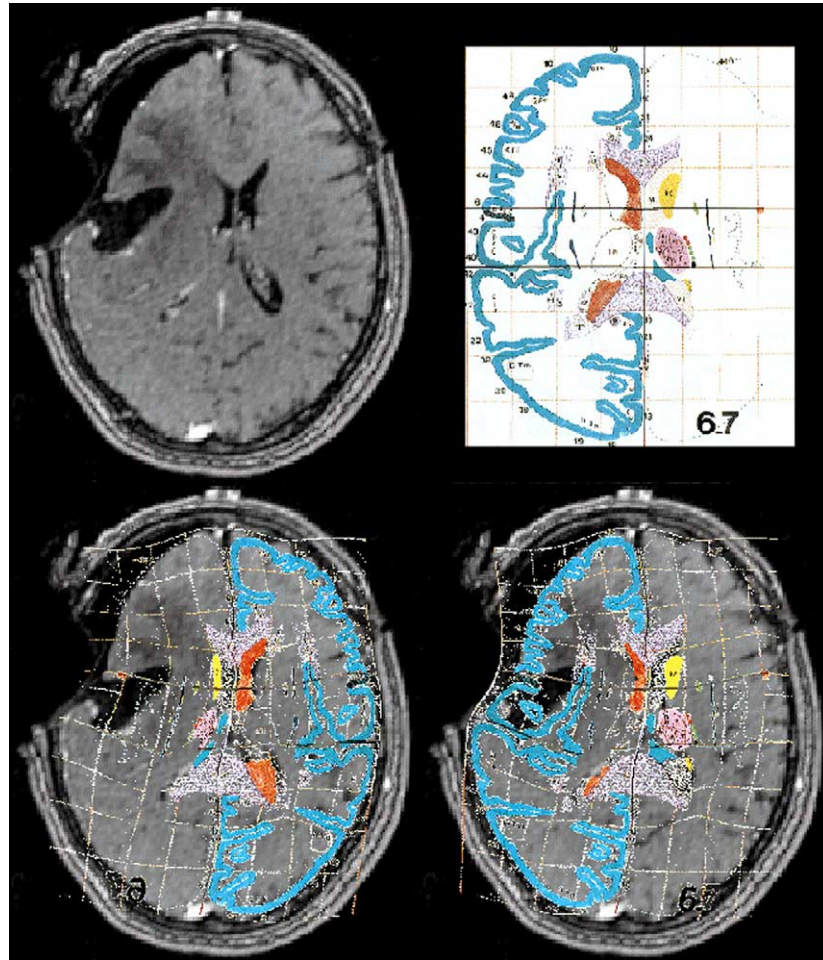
The atlas was matched nonrigidly to a MRI dataset acquired during surgery. The atlas compensates the large deformation (brain shift) caused by the intervention. Top row: axial image (left), original axial plate from the atlas of Talairach and Tournoux (1988) (right). Bottom row: transparent overlay of the nonrigidly deformed plate on both hemispheres. In the insula as well as at the left ventricle the matching seems to be inaccurate. This can be explained as follows: (i) the insula is relatively far apart from the given point correspondences, so the amount of uncertainty is relatively big; (ii) the axial atlas plate is deformed not only in-plane, but also perpendicular to the plane (a similar effect can be seen for coronal and sagittal plates in Fig. 13). The image of course depicts a projection of the deformed plate onto a plane MR cross-section, while the actual distance between MR image and deformed plate at some locations is up to several millimeters. (This figure is available in colour, see the on-line version.)
